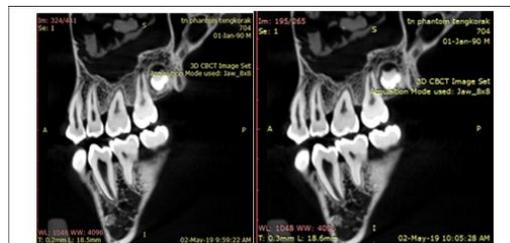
CBCT images of skull scan before Image-J filtering
